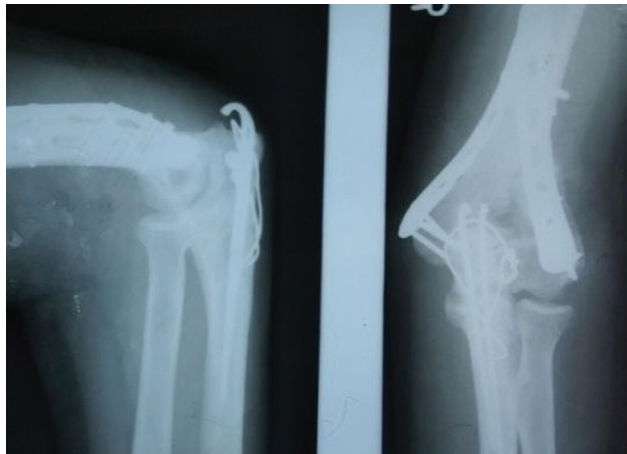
Case1: transolecranon approach; X-Ray at the last follow-up.
